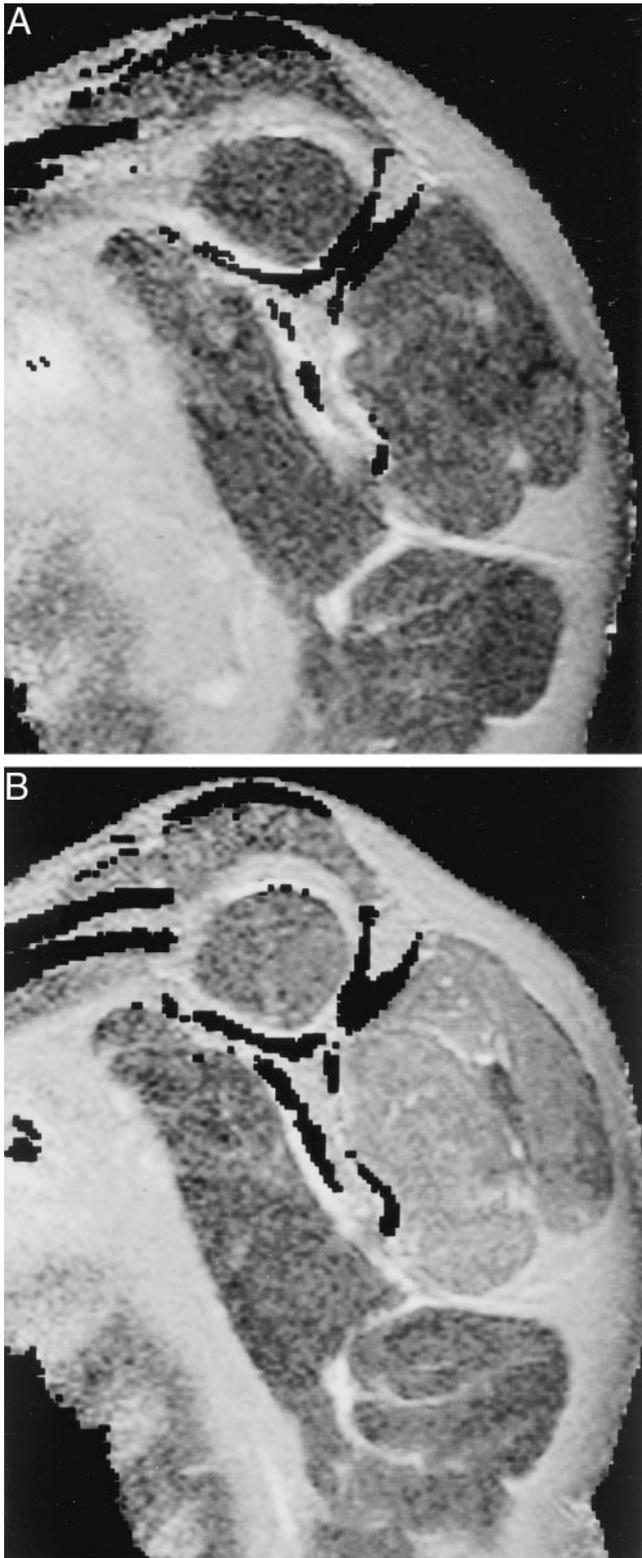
The T2-weighted calculated oblique sagittal images before (A) and after (B) the horizontal abduction exercise. Relaxation time for the supraspinatus was 29.0 ms (before the exercise) and 34.3 ms (after the exercise) for this subject.
